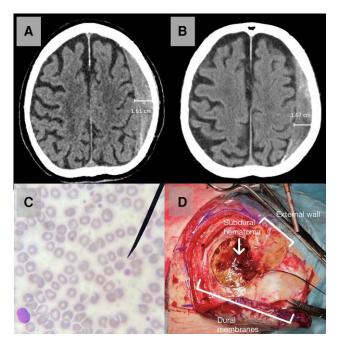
A, Computed tomography (CT) brain at 10 months earlier revealed a crescent-shaped hypodensity mass with a slight hyperdensity representing trace of acute hemorrhage in chronic subdural hematoma, no midline shift or other evidence for brain herniation; B, CT brain in this admission showed enlargement of subdural hematoma at left frontal and parietal convexities, representing worsening acute-on-chronic subdural hematoma; C, peripheral blood smear showed normocytic normochromic red blood cells and thrombocytopenia; D, intraoperative craniotomy revealed the intact inner membrane of multistage subdural hematoma.
